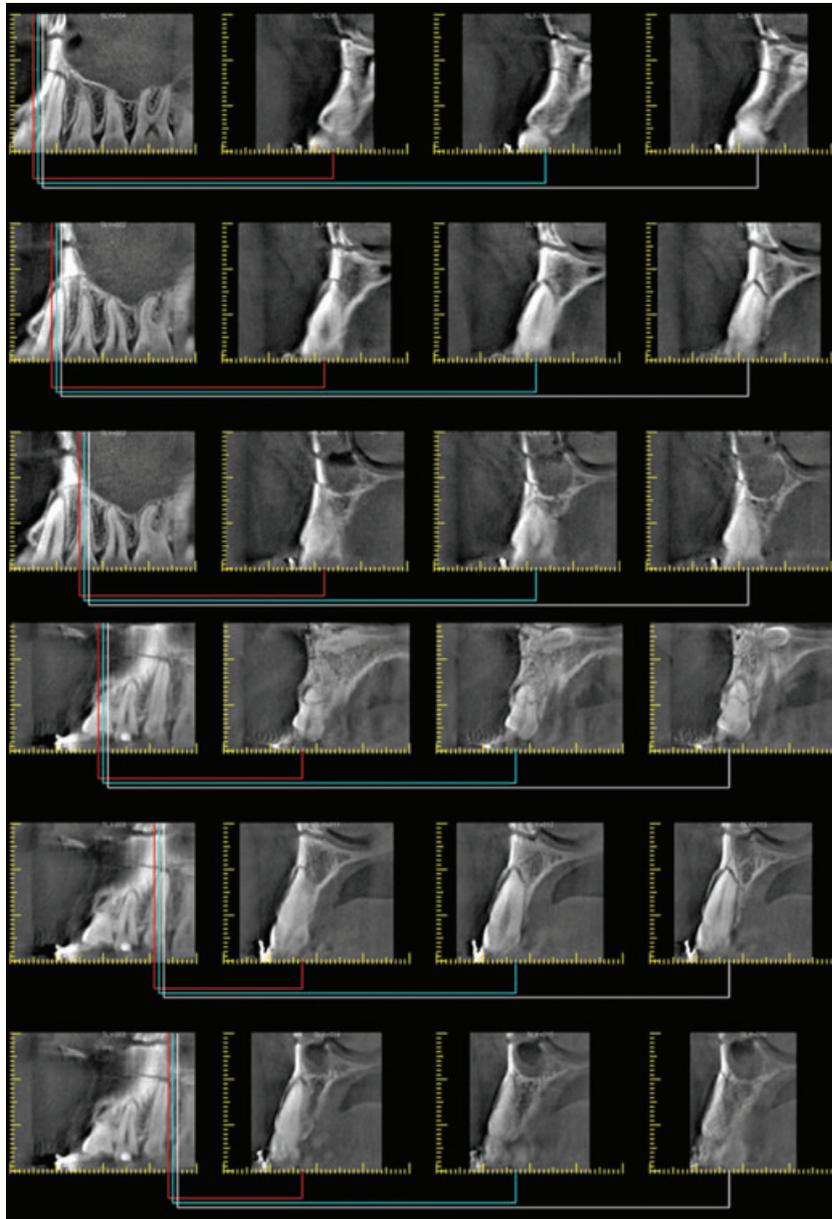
Midface fracture (Le Fort 1) with alveolar and dental involvement. This small volume cone-beam computed tomography presents high resolution providing images with high details.
